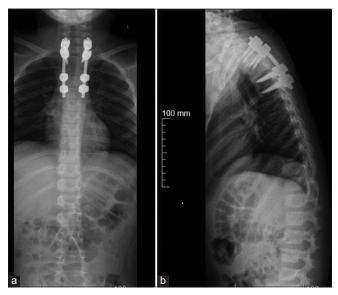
Immediate post-operative radiograph; (a) anteroposterior and (b) lateral radiographs showing posterior spinal instrumentation from T1 to T5 with excellent coronal and sagittal alignment.
